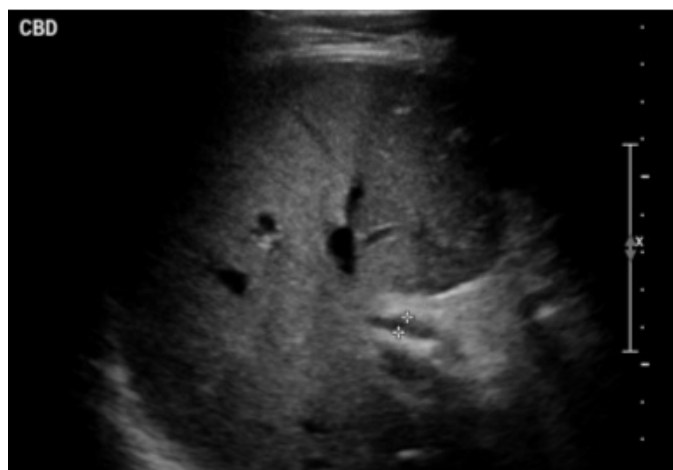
Ultrasound examination of the abdomen shows a normal CBD measuring 5 mm (Case 3).
